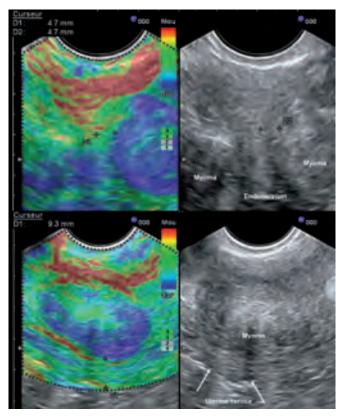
Color mapping of uterine strain allows precise determination of the so-called "security wall" between the fibroids and the endometrium or uterine serosa before surgical resection with laparoscopy or hysteroscopy respectively *Source*: Ami O, Lamazou F, Mabille M, et al. Real-time transvaginal elastosonography of uterine fibroids. Ultrasound Obstet Gynecol. 2009;34:486-8
